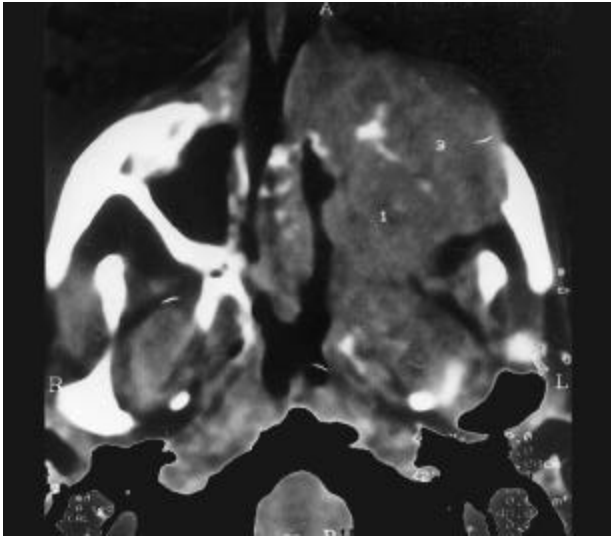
CT scan head showing an enhancing mass in the right maxillary sinus which is destroying its wall.
